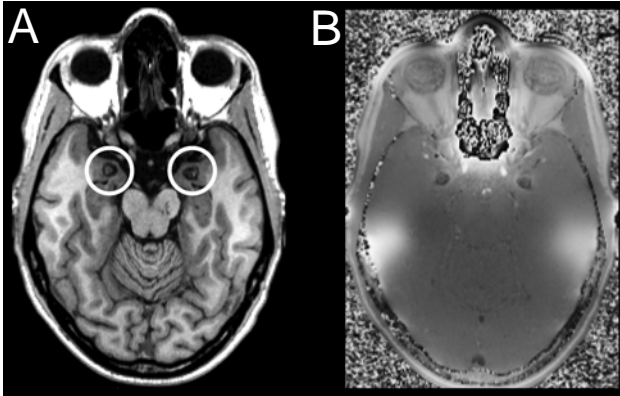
Horizontal MRI sections of the anterior medial temporal lobe; the white circles index the selective bilateral amygdala calcification lesions in a patient with Urbach-Wiethe disease (hyalinosis cutis et mucosae, lipoproteinosis) (OMIM 247100). Shown are magnitude (A) and phase (B) images derived from a reconstructed 5-average MRI data set acquired with 0.8 mm isotropic resolution.
